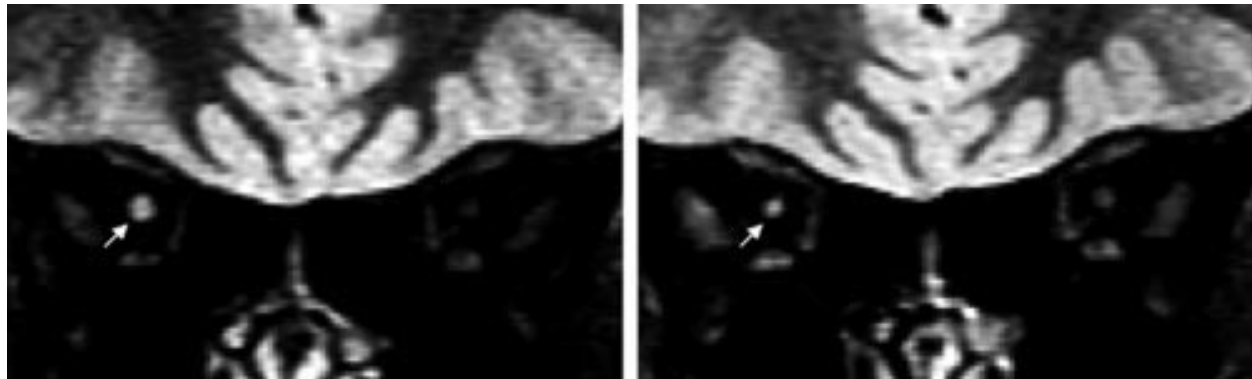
Short tau inversion recovery magnetic resonance images showing optic nerve swelling at baseline (left) and optic nerve atrophy after six months (diseased nerve arrowed) in a 27 year old man with right optic neuritis.
